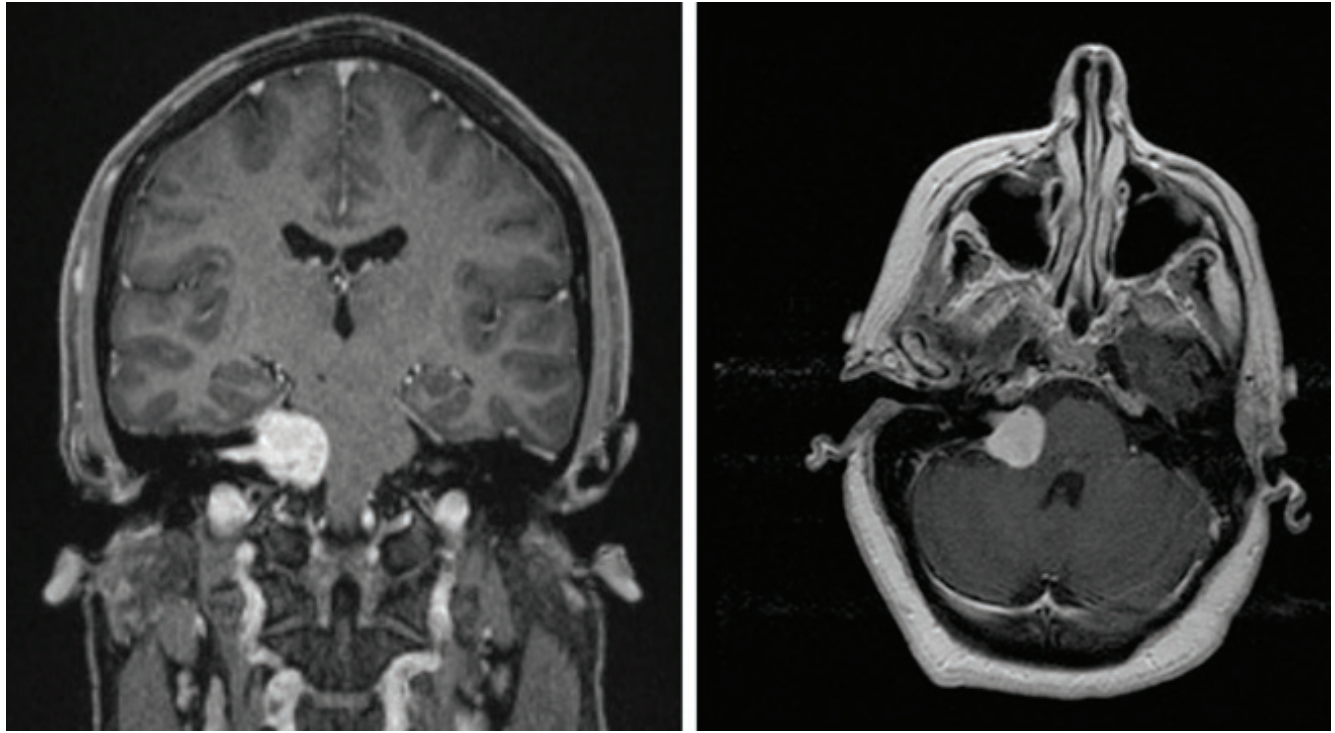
MRI scan showing a 3 cm right intra- and extrameatal vestibular schwannoma, touching the brainstem.
